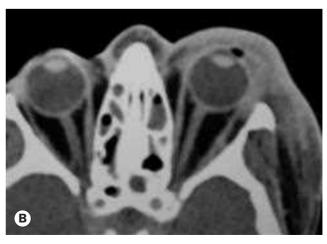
Preseptal cellulitis. (A) Left preseptal cellulitis resulting from an infected eyelid abrasion; (B) axial CT showing opacification anterior to the orbital septum
